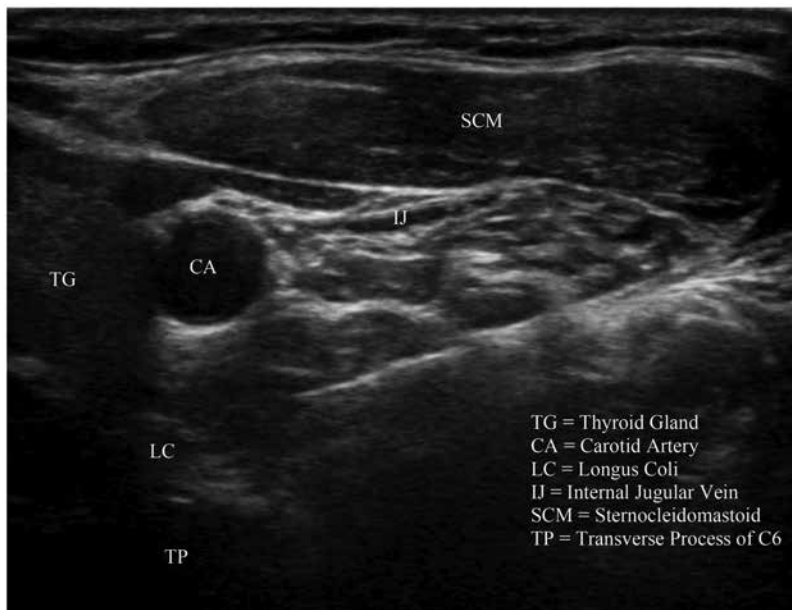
Ultrasound demonstrating the performed stellate ganglion block.
